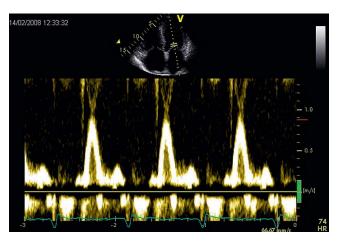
Transthoracic echocardiography demonstrating LV restrictive filling pattern in a patient with amyloid cardiomyopathy. The dominance of early mitral inflow velocity with decreased deceleration time < 150 ms is seen (apical 4-chamber view).
